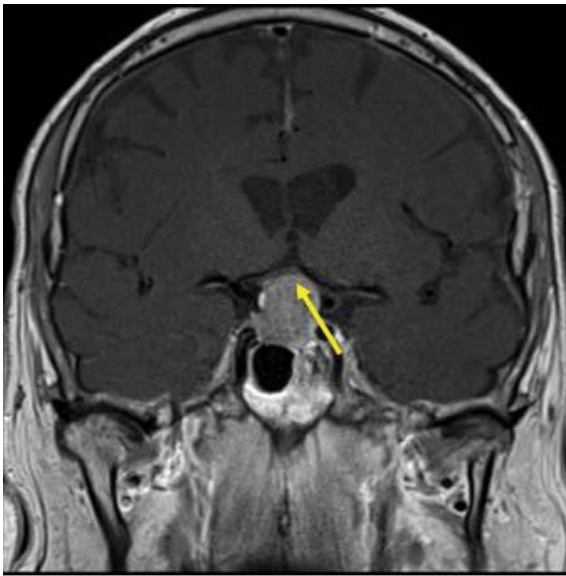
MRI Brain sagittal image: Yellow arrow represents where the 1.5X1.3X2.4 cm sellar/suprasellar mass expanding the sella with suprasellar extension leads to elevation and thinning of the optic chiasm consistent with pituitary adenoma.
